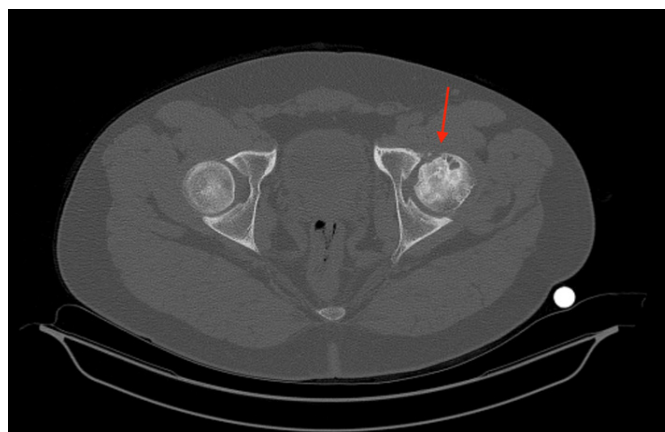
CT showing osteonecrosis of the left femoral head
